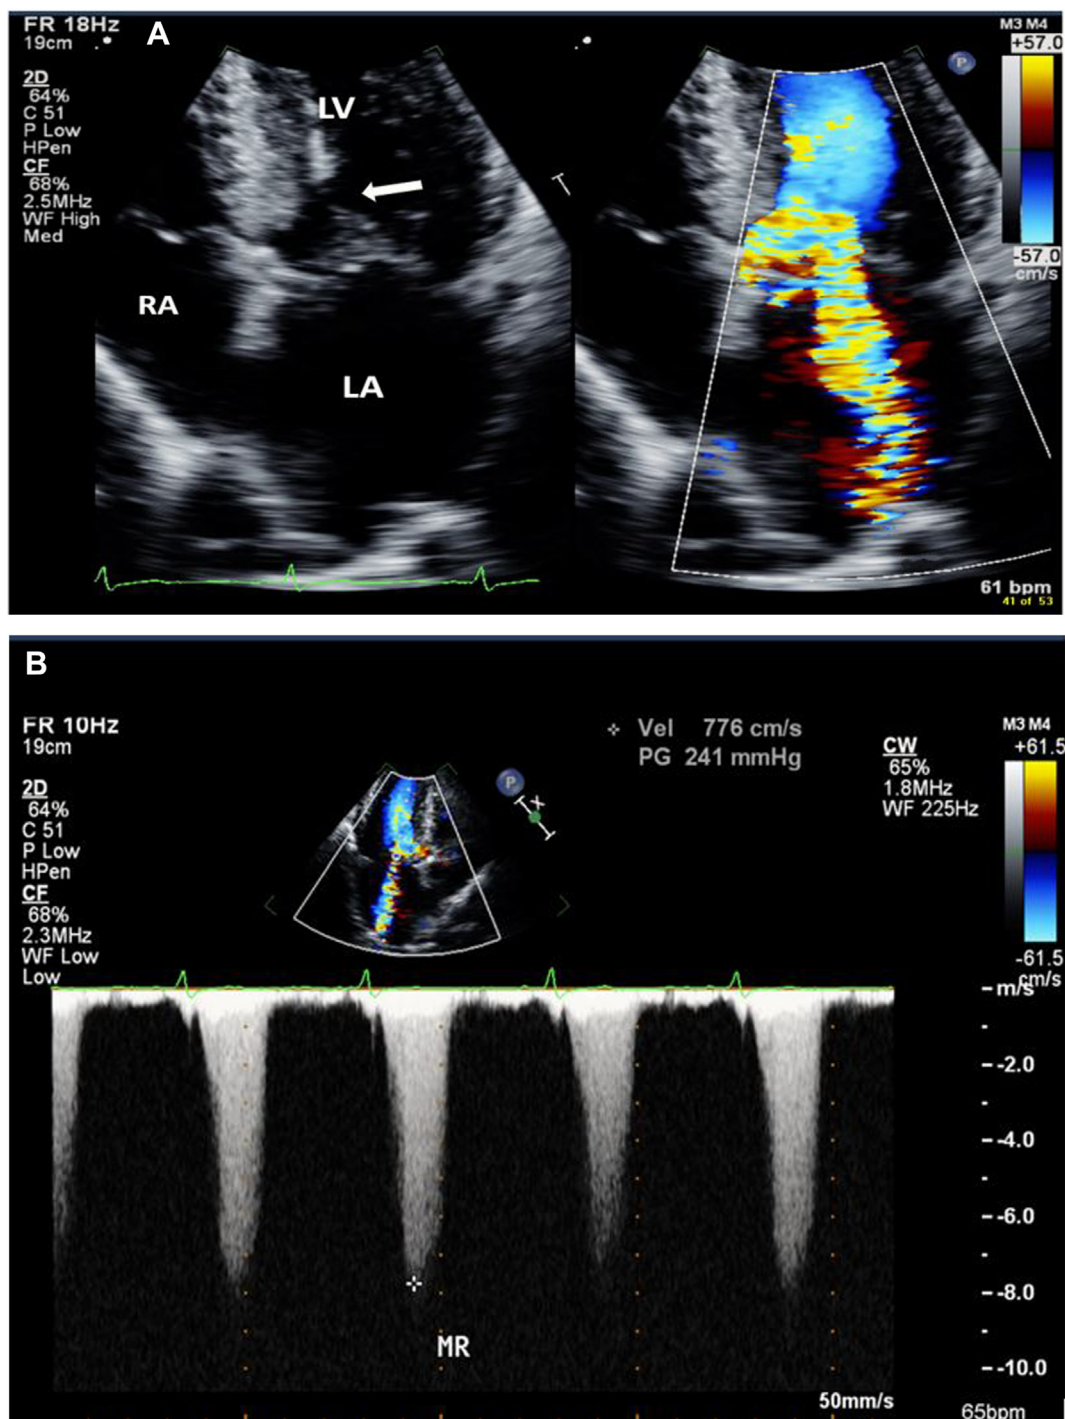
Case 1: (A) Two-dimensional TTE, apical four-chamber systolic view without (*left*) and with (*right*) color flow Doppler, demonstrates SAM of the anterior MV leaflet (*arrow*) with at least moderate MR and aliasing in the LVOT. (B) CWD across the MV demonstrates a spectral display with a high-velocity, late-peaking spectral profile from the MR jet (7.8 m/s, 241 mm Hg). LA, Left atrium; LV, left ventricle; RV, right ventricle.
